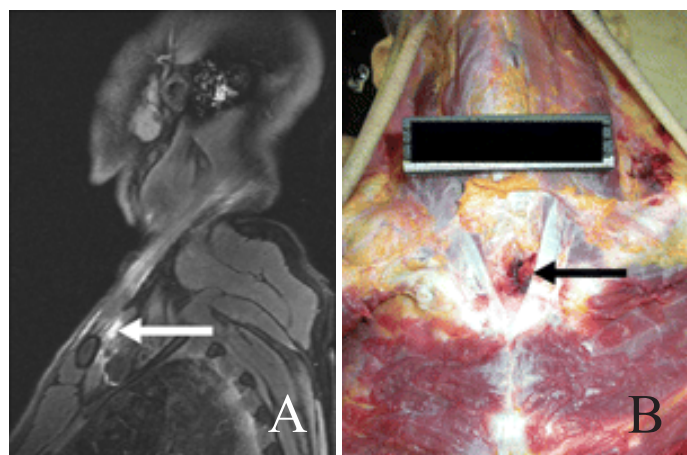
(a & b): Vital signs in a case of suicide by hanging. (3a) Sagittal T2-weighted MR image shows areas of hyperintensity (arrow) around the sternoclavicular insertions of the sternocleidomastoid muscle. (3b) Autopsy photograph reveals areas of bleeding (arrow) around the insertions of the sternocleidomastoid muscle, findings that indicate ongoing circulation at the onset of strangulation.
